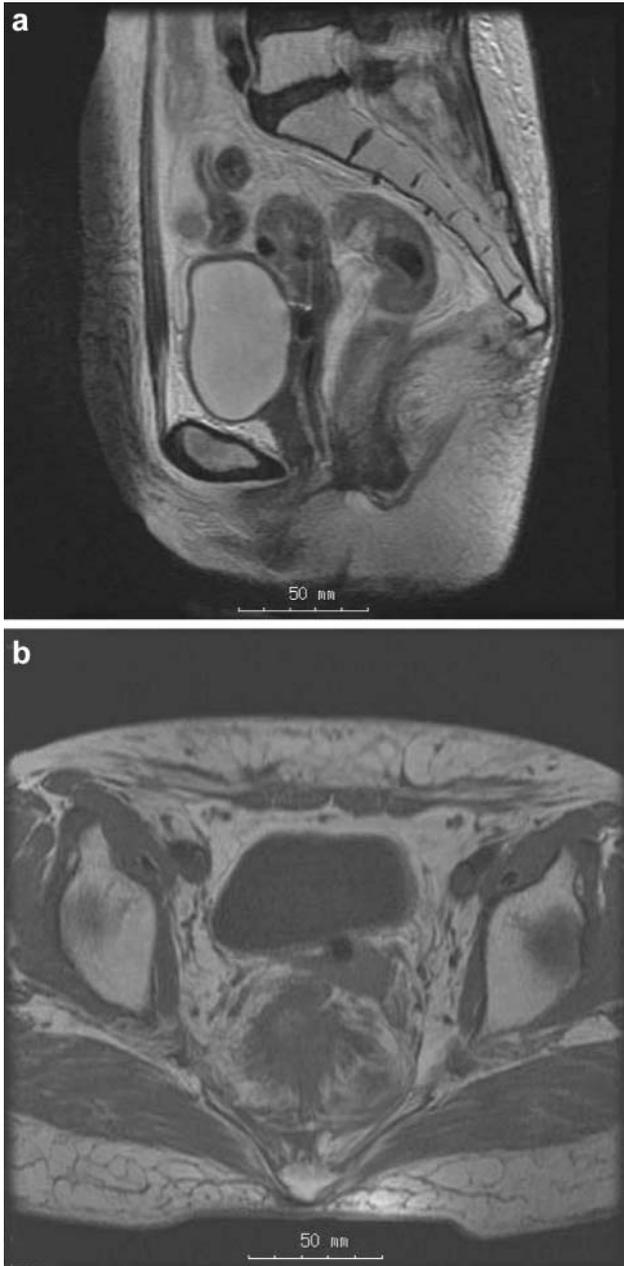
Magnetic resonance imaging of the pelvis after the radiation therapy. Bulky cervical tumor had disappeared. This is a sagittal image of T2WI (a). This is an axial image of T2WI (b).
